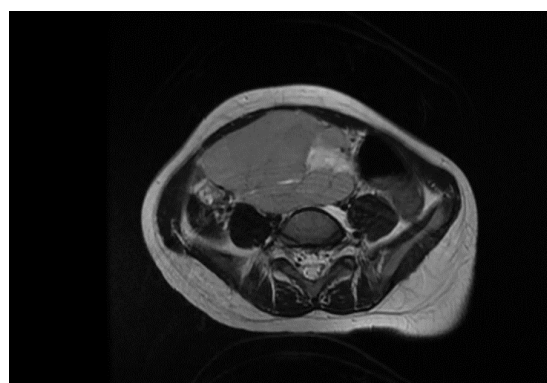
The axial view of an abdominal MRI
